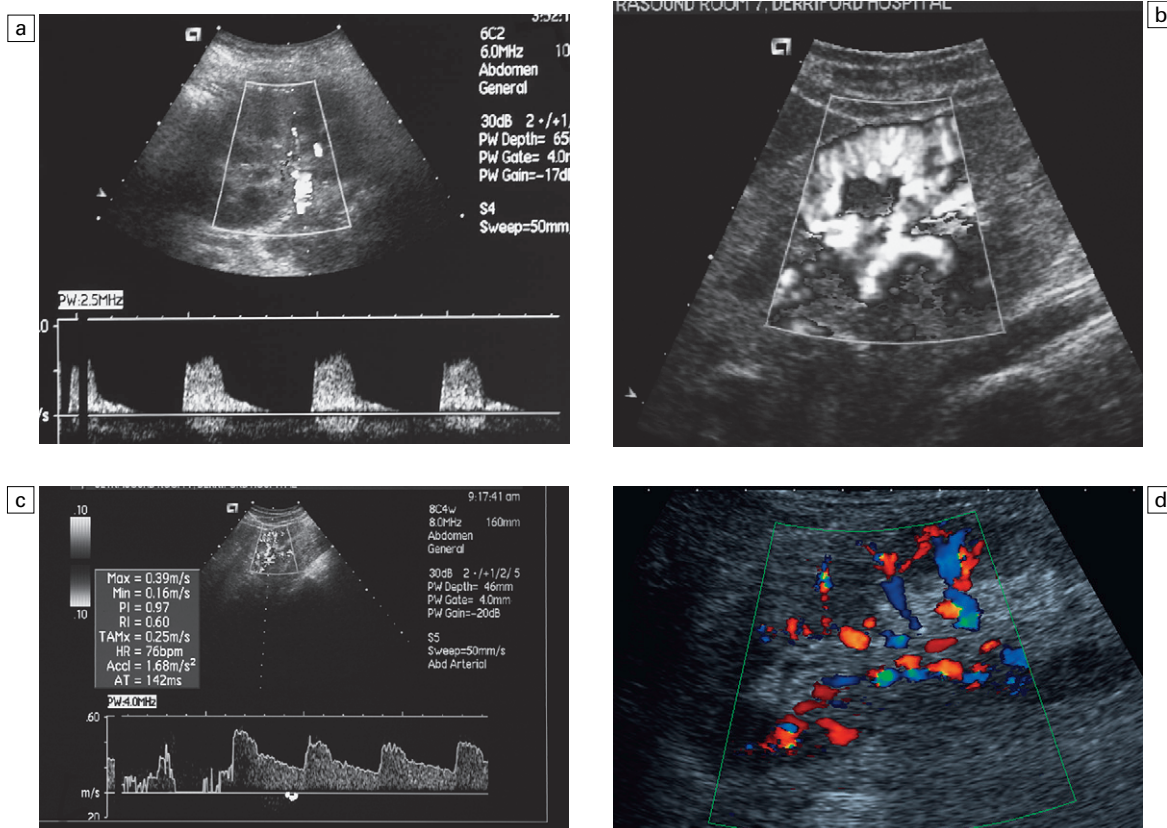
(a) Diffuse parenchymal renal disease. The patient presented with raised creatinine. There is absent diastolic flow. (b) and (c) Power Doppler and spectral Doppler in a patient with early diabetic nephropathy. The kidney is well perfused. (d) Patchy colour perfusion of a patient with diffuse parenchymal renal disease. Current resolution does not afford the clear demonstration of intrarenal shunting.
